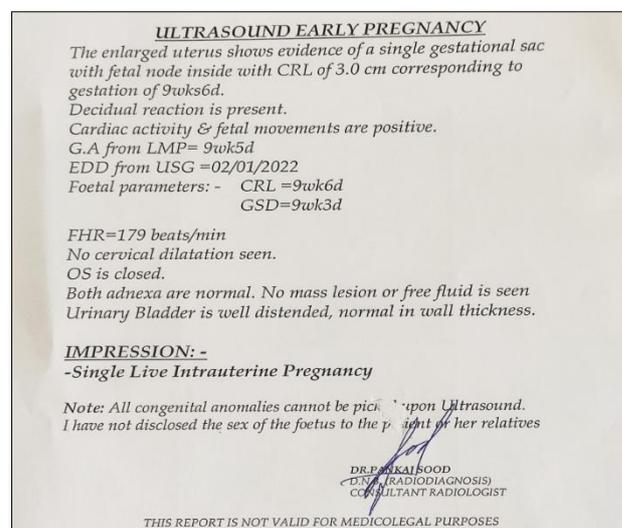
Ultrasonography report after conception
